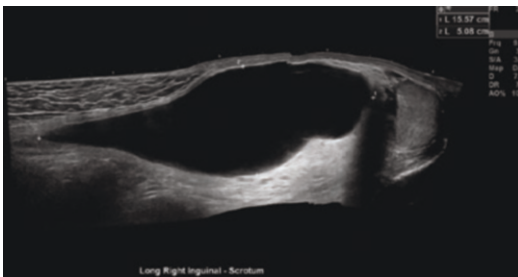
Extended field of view longitudinal ultrasound image depicting hernia distended with ascites
